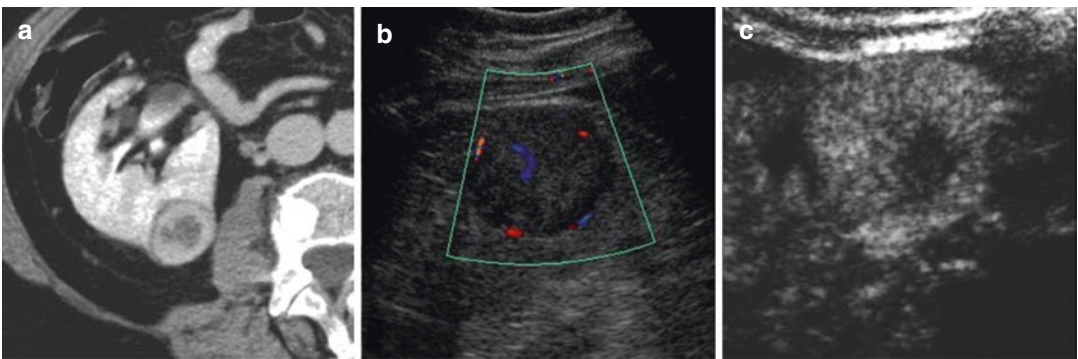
Contrast-enhancement CT scan shows a heterogeneous solid lesion, with intense peripheric enhancement (a). Colour Doppler examination shows an increased vascularisation, both intralesional and peripheral (b). CEUS demonstrates an intense peripheral hyperenhancement, suggestive of renal clear cell carcinoma (c)
